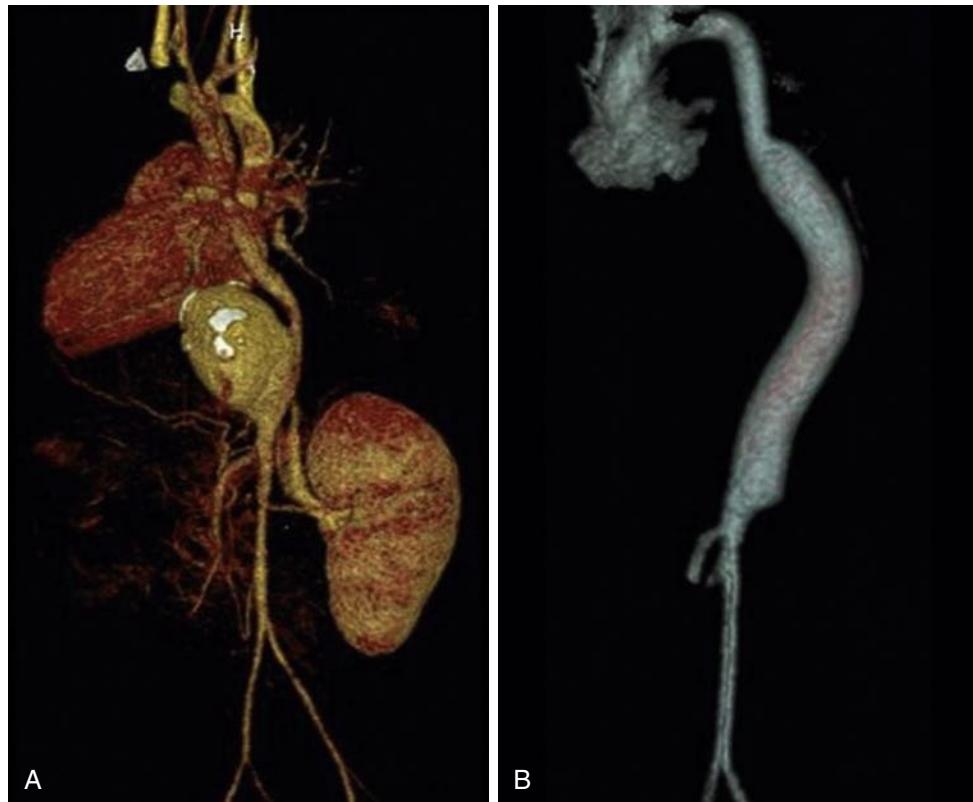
(A) Saccular mycotic aneurysm of the supraceliac abdominal aorta in a 20-month-old associated with infected umbilical artery catheterization (computed tomography angiography). (B) Magnetic resonance angiography following aneurysmectomy and repair with interposition 12-mm expanded polytetrafluoroethylene graft. (From Eliason JL, Coleman DM, Criado E, Stanley JC. Surgical treatment of abdominal aortic aneurysms in infancy and early childhood. *J Vasc Surg*. 2016;64:1252–1261.)
